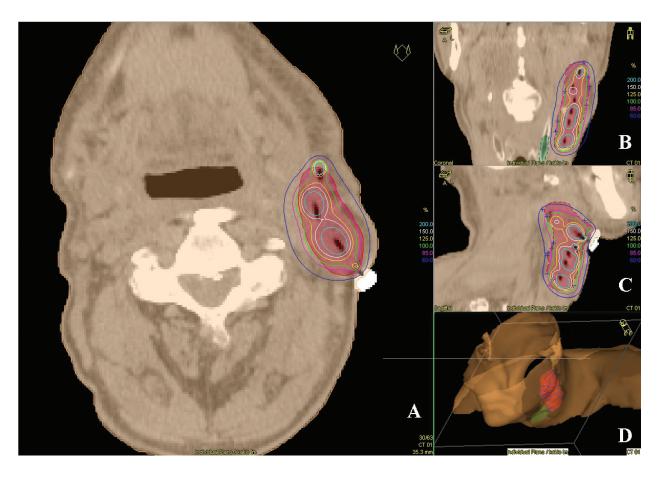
HDR-BRT dosimetric plan shown on axial (A), coronal (B) and sagittal (C) CT slice, 3D view of PTV (red) (D) for a patient with isolated neck recurrence of tonsil squamous cell carcinoma. PTV volume was 37.85 cm³, V100 = 85.89%, V150 = 32.28%, V200 = 12.1%, HI = 0.62, DNR = 0.37.
